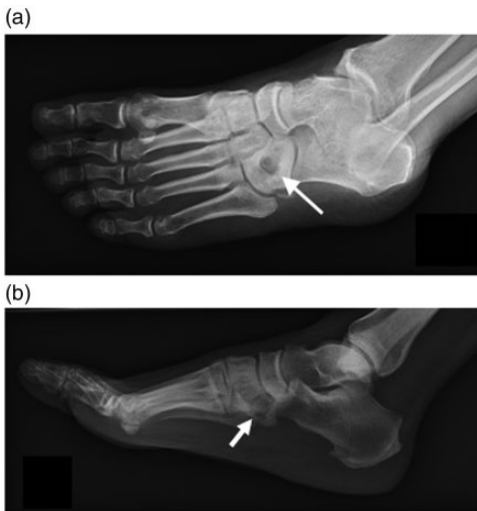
Plain radiography (a: oblique view; b: lateral view) of the injured right foot showing an osteolytic lesion over the cuboid bone (arrows) and no signs of a foreign body in the plantar region.
